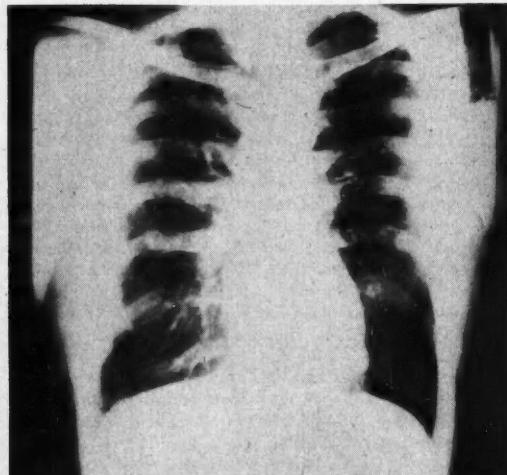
Roentgenogram made April 16, 1951. The right lung field was completely cleared.
